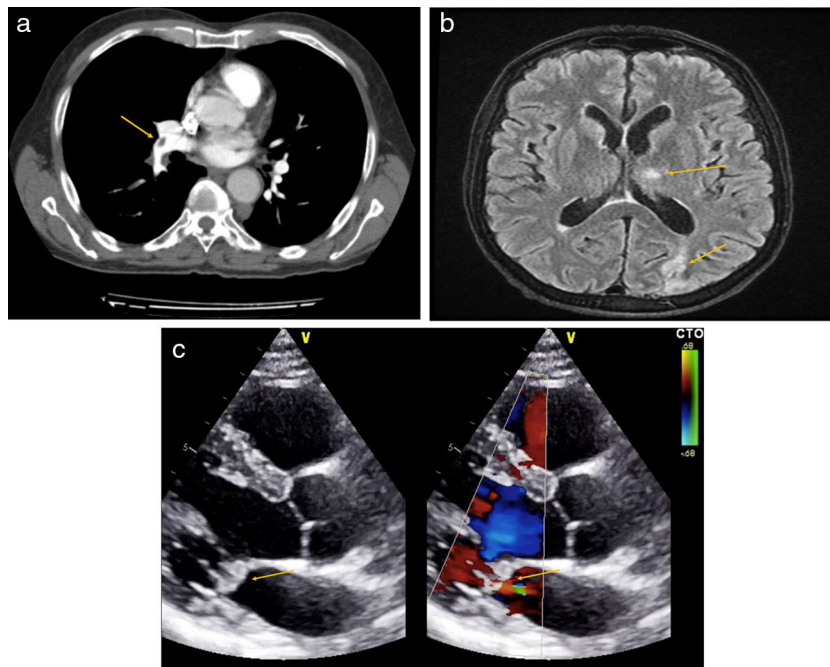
(a) CT angiography of pulmonary arteries. Filling defect in arteries of the right and left lower lobes consistent with PTE, arrow. (b) Brain MRI in T2. Ischemic impacts in cerebellar hemispheres and in the occipital region, arrows. (c) Echocardiogram in the long parasternal axis. Severe mitral insufficiency and endocardial masses on mitral valve, indicated with arrows.
